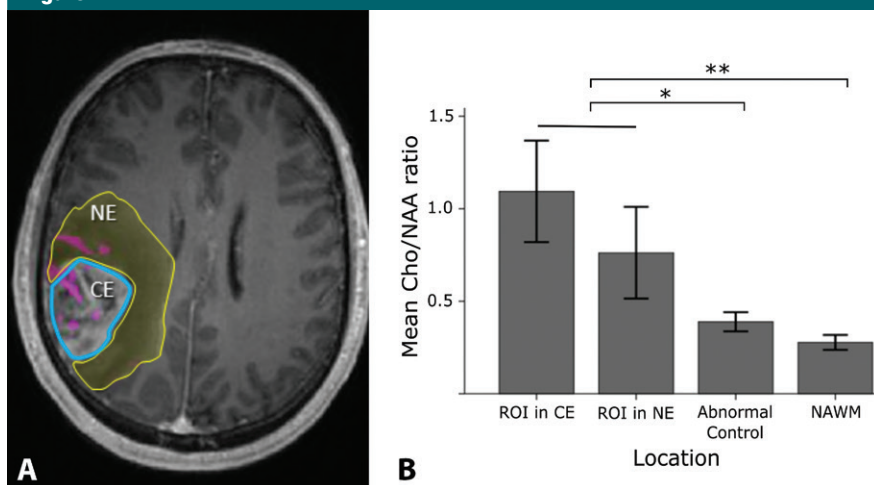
A, MR image shows boundaries of contrast enhancement (CE) (blue) and nonenhancement (NE) (yellow) used to categorize the ADC-rCBV ROI (magenta) Cho/NAA ratio according to location. B, Means plot shows results from the posthoc homogeneous subset tests, with Cho/NAA ratio from contrast-enhanced and unenhanced areas in a separate subset from Cho/NAA ratio from abnormal control tumor regions and normal-appearing white matter (NAWM). Lines extending from the bars show standard error of the mean. * = $P < .01$,  = $P < .001$.
